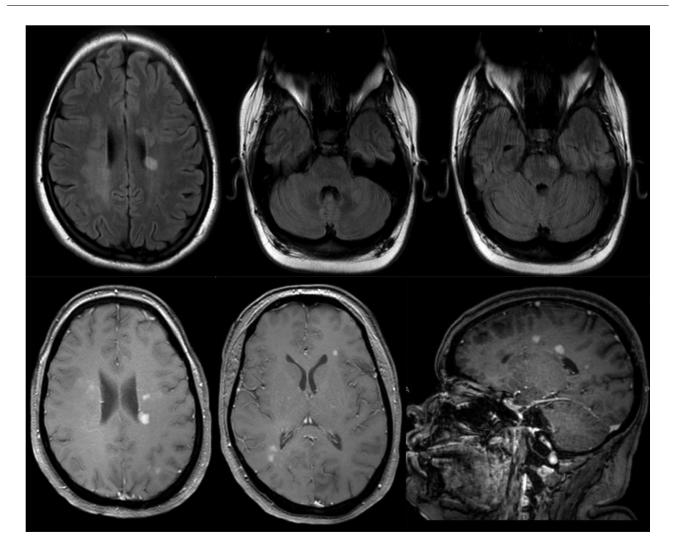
First MRI. Hyperintense lesions on T2/FLAIR sequence, involving periventricular white matter (a), left cerebellar hemisphere (b) and left pontine base (c). Diffuse hyperintense lesions on T1 sequence, involving periventricular white matter in the parietal (d), frontal and occipital lobe (e), and ovoid high signals perpendicular to the lateral ventricle, also known as Dawson fingers (f).
